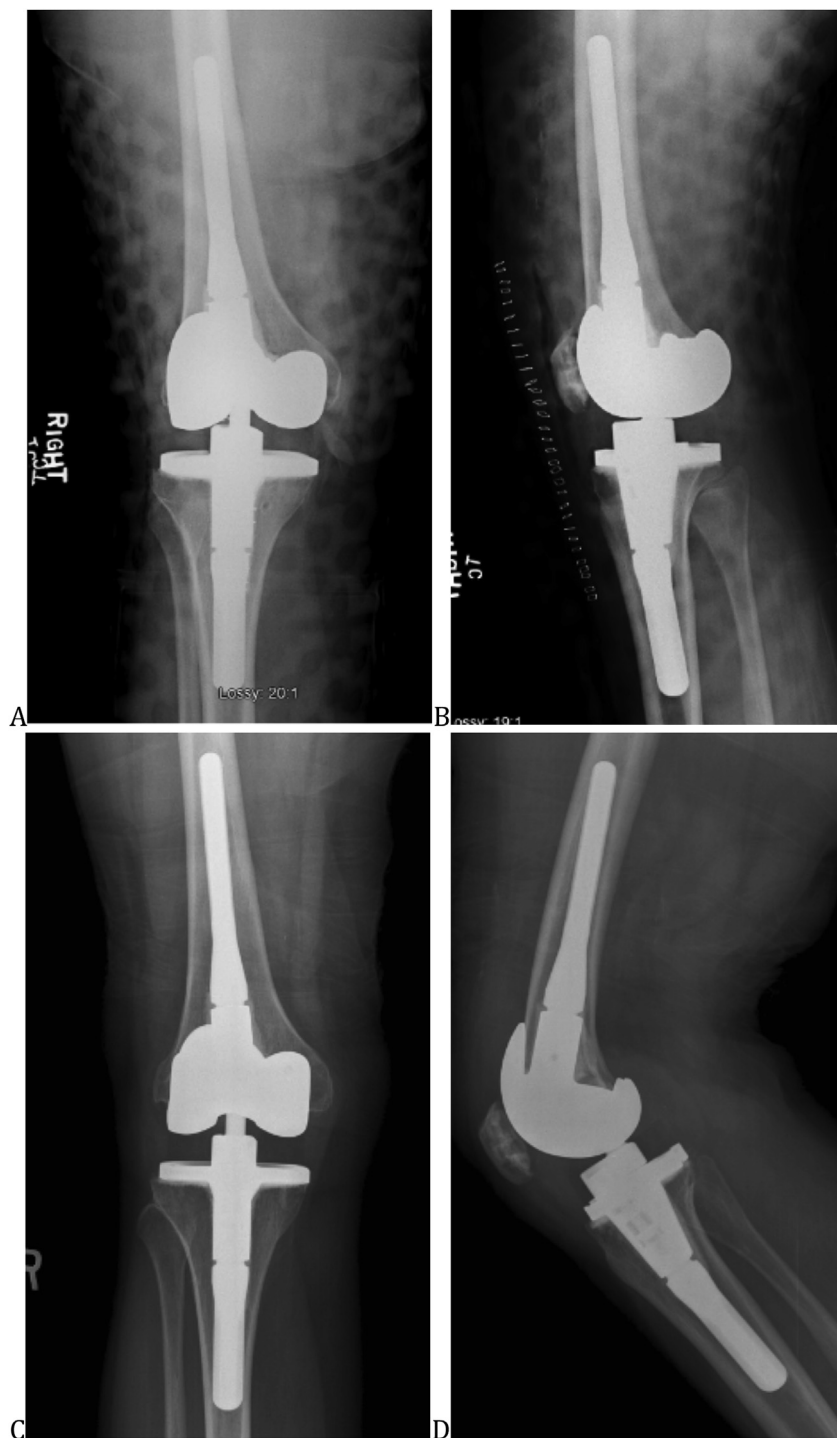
The immediate postoperative AP (A) and Lateral (B) x-rays of a patient were independently evaluated and compared to AP (C) and Lateral (D) x-rays at follow up by a radiologist.
